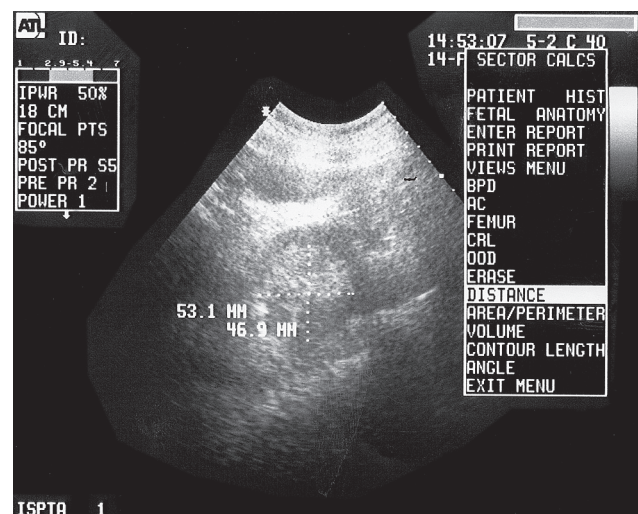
Abdominal ultrasound: hyperechoic structure, well delimited, inside the rectal lumen.
